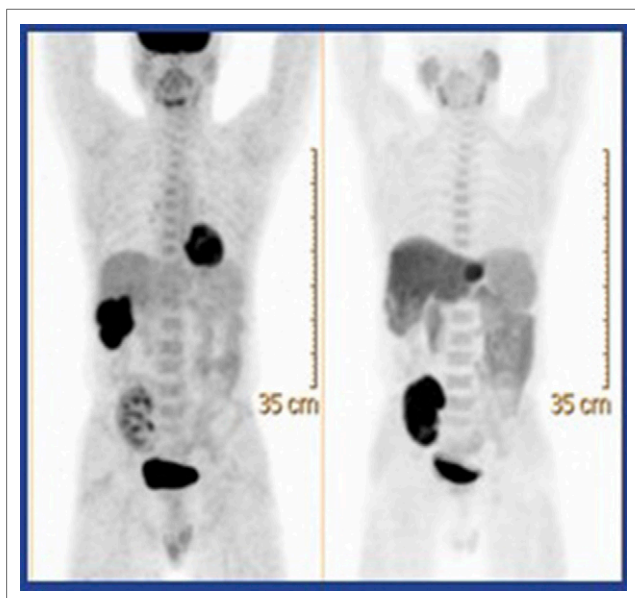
^{18}F -FDG (left) and ^{18}F -FCH (right) PET images of a 63-year-old man with HBsAg (+) after renal transplantation with hepatocellular carcinomas in segment 6 and two-thirds of the liver. Individual lesions expressed variable FDG and FCH avidity.
